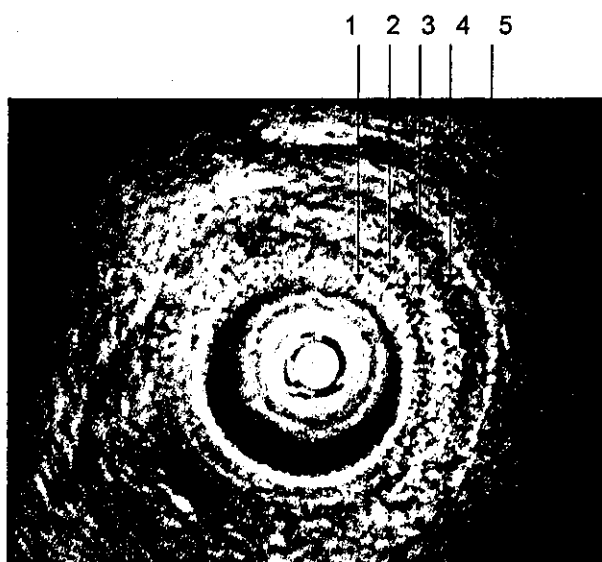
Representative endobronchial ultrasonogram showing a laminar structure of the bronchial wall. A central circular lesion is an echo probe, and a five-layer laminar structure is depicted. The first lamina is a hyperechoic layer representing the balloon sheath and the bronchial epithelium; the second lamina is hypoechoic layer representing the submucosal layer and the bronchial smooth-muscle layer; the third lamina is a hyperechoic layer representing the marginal echo of the luminal aspect of the bronchial cartilaginous layer; the fourth lamina is a hypoechoic layer representing the bronchial cartilaginous layer; and the outermost (fifth) lamina is composed of a hyperechoic layer representing the marginal echo of the outer cartilaginous layer and the outer margin of the bronchial wall. Numbered arrows indicate the layers of the bronchial wall as mentioned above.
